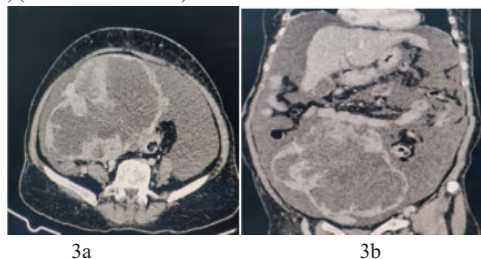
A 52-year-old female with complaints of severe abdominal pain and distension since 2 months. Contrast enhanced CT imaging of abdomen and pelvis showed large solid cystic necrotic lesion with nodular wall enhancement, superior displacement of bowel loops by the mass and gross ascites in abdomen and pelvis (3a- axial section and 3b-coronal section)
